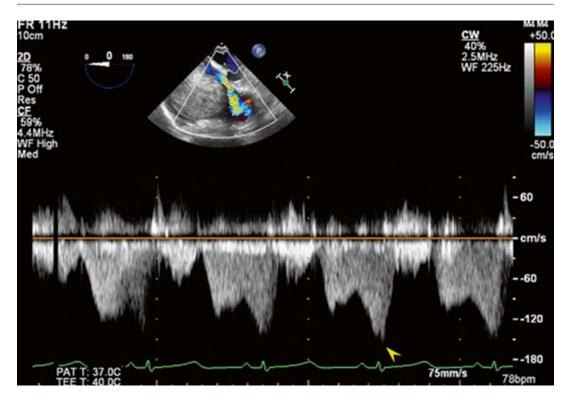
2D TEE continuous-wave Doppler of TV, TS with high gradient tricuspid inflow (arrow) was present
